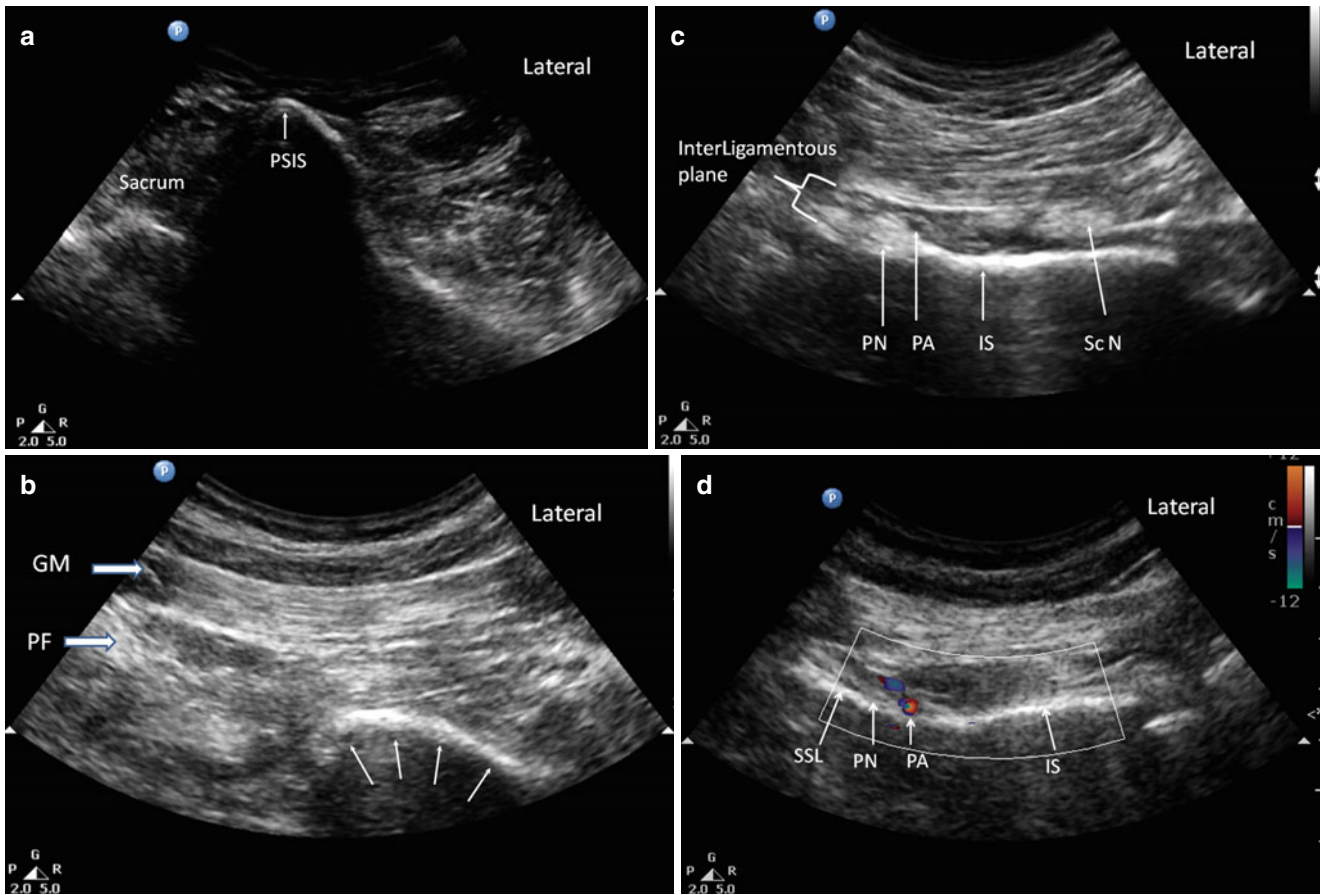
(a) Ultrasound image at probe position A. (b) Ultrasound image at probe position B. *Line arrows* indicate the ischium, which is curved as it forms the posterior portion of the acetabulum. (c) Ultrasound image at probe position C. (d) Color-flow Doppler to show pudendal
